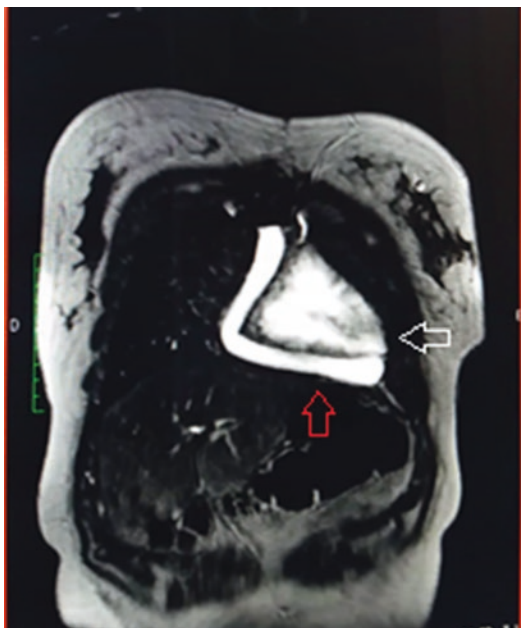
MRI after the ascending-to-descending bypass shows the graft (*red arrow*) descending next to the right margin of the heart, anteriorly to the IVC, and then making a curve on the apex (*white arrow*)
